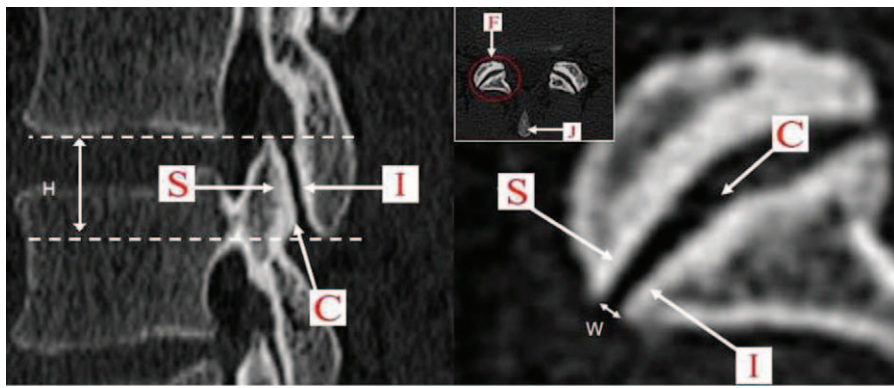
CT image of normal facet joints. The left is the CT image of the parasagittal plane of the normal facet joints. The right is the CT image of the transverse section of the normal facet joints. Notes: S indicates superior articular process, I indicates inferior articular process, C indicates articular cartilage, J indicates spinous process of lumbar vertebrae, and F indicates facet joint. The articular surface of superior and inferior articular process is smooth, regular, and high-density. The low-density fissure between articular processes is articular cartilage.
